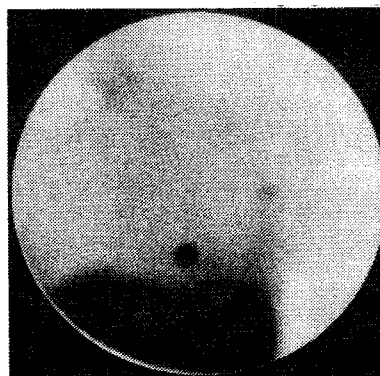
[^{111}In -DTPA-D-Phe 1]-octreotide scintigraphy of a 39-year-old patient showing breast cancer on the left side and axillary-node metastases.
